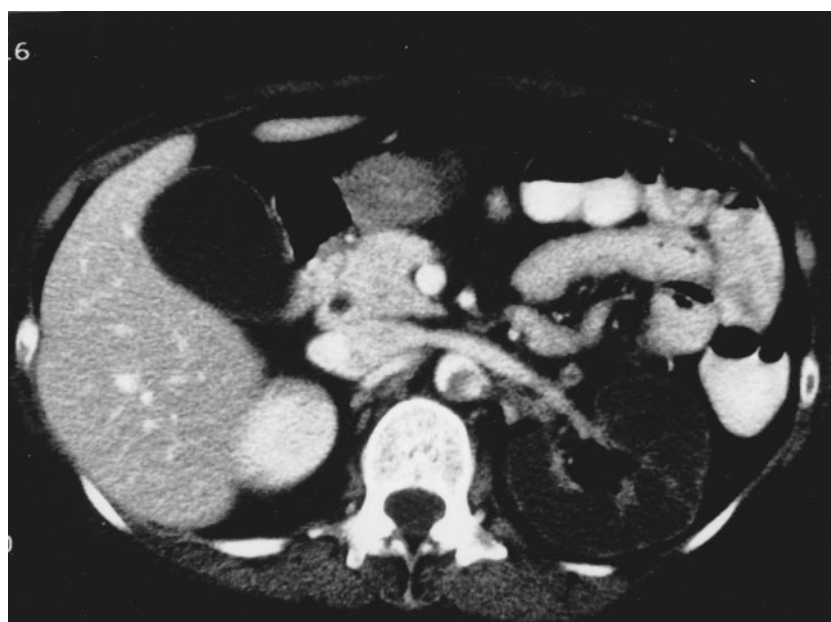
Contrast CT of the abdomen shows a non-enhancing ischemic left kidney due to infarction, with thin cortical rim enhancement related to collateral capsular supply. Thromboembolus within the left renal artery is seen projecting into the lumen of the adjacent abdominal aorta.
